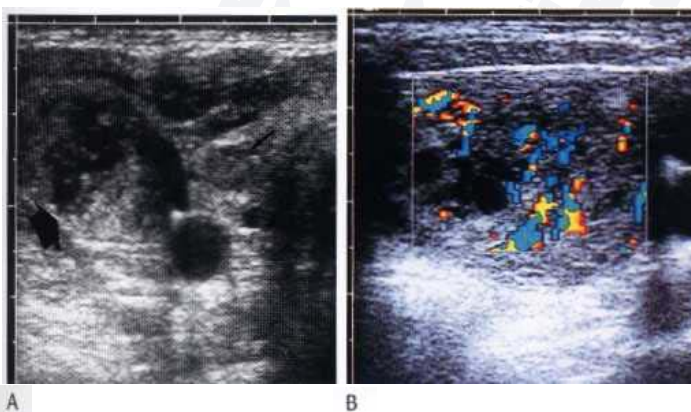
(A) Transverse ultrasound scan of the lower pole of the right lobe of the thyroid with a small hypoechoic mass (arrow). There is an adjacent level four nodal metastasis which is larger than the primary papillary cancer and shows cystic change and abnormal vascularity (B).
